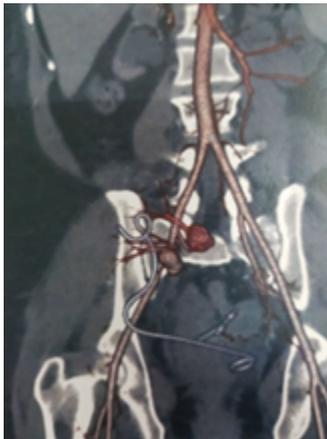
Computed tomogram showing right external iliac artery pseudoaneurysm (mycotic)
